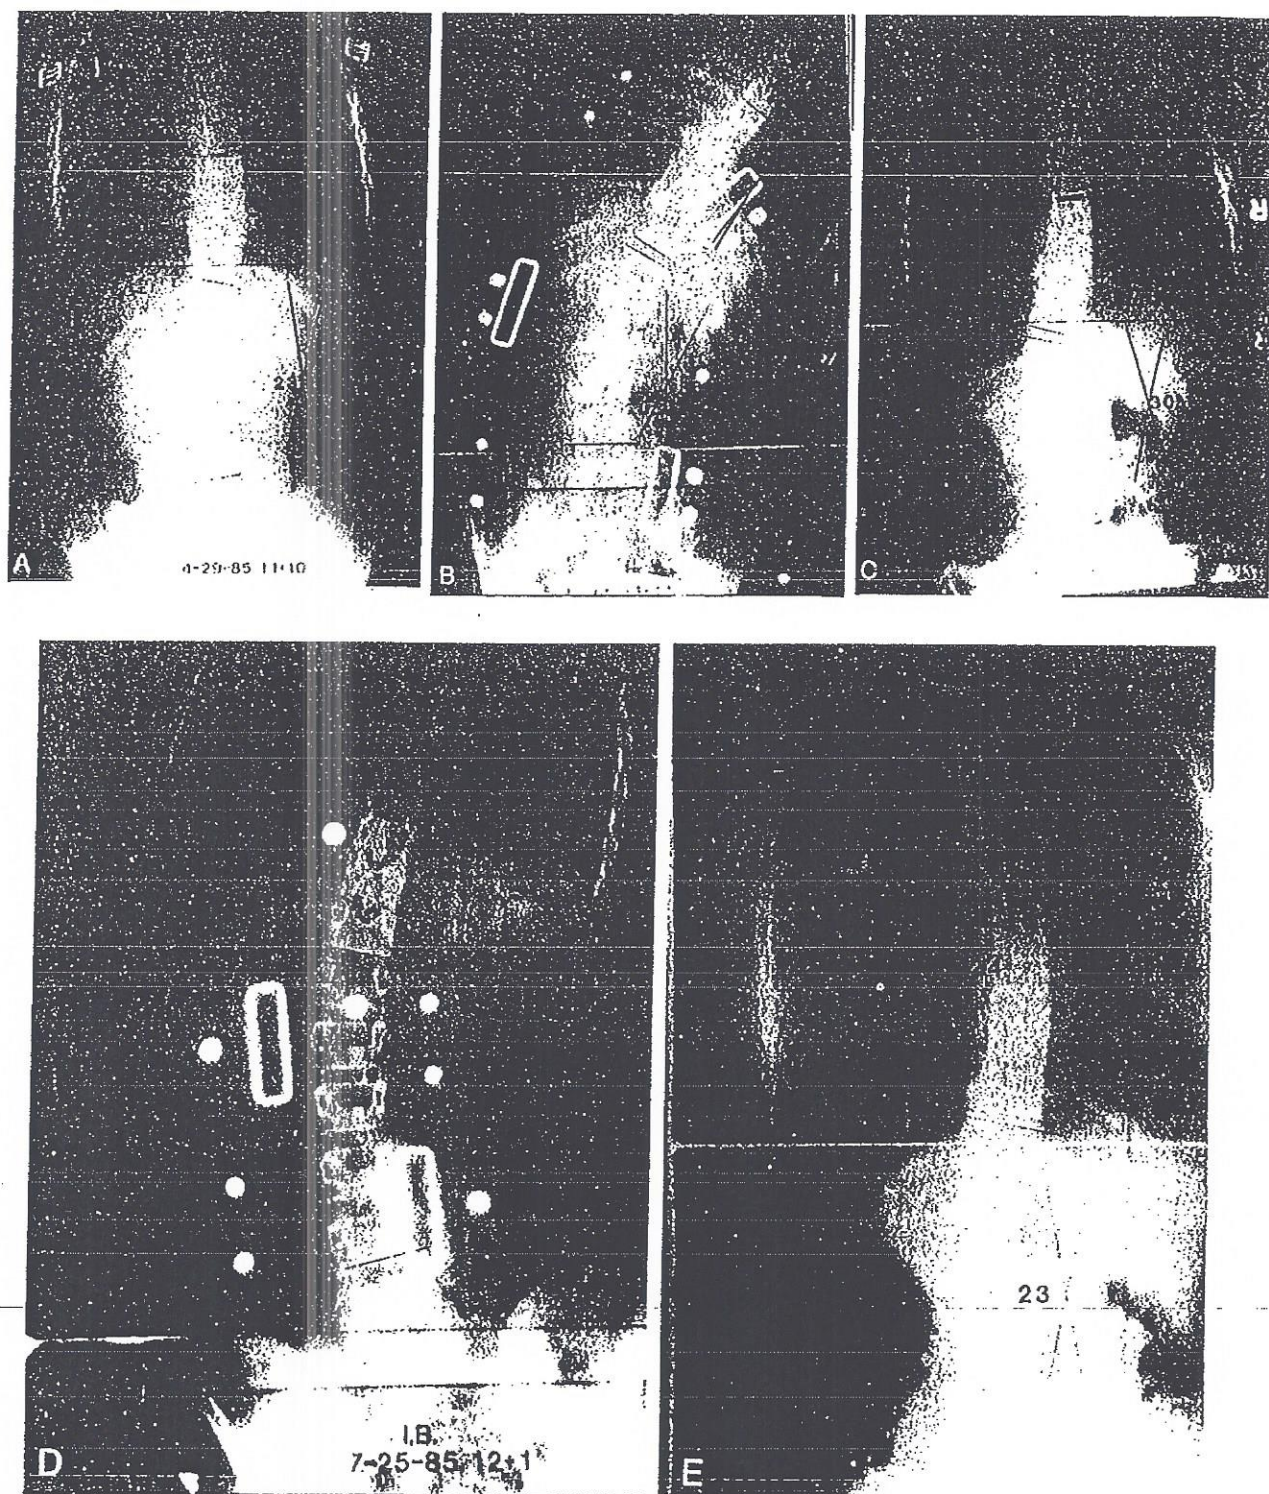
Compensatory curves may be increased by poor bracing technique: A, 11-year, 10-month-old girl with 25° right thoracic scoliosis, which had progressed from 17°. Compensatory lumbar curve measures 23°. B, Radiograph in initial Charleston bending brace. Note that the compensatory curve is increased to 30° in the brace. C, Out of brace radiograph 2 months later demonstrates progression of lumbar curvature. D, Radiograph in new orthosis demonstrates correction of both curvatures. Thoracic curve measures 0°. Lumbar curve measures 23°. E, Eight months after completion of brace treatment the thoracic curve measures 24° and the lumbar curve measures 23°.
